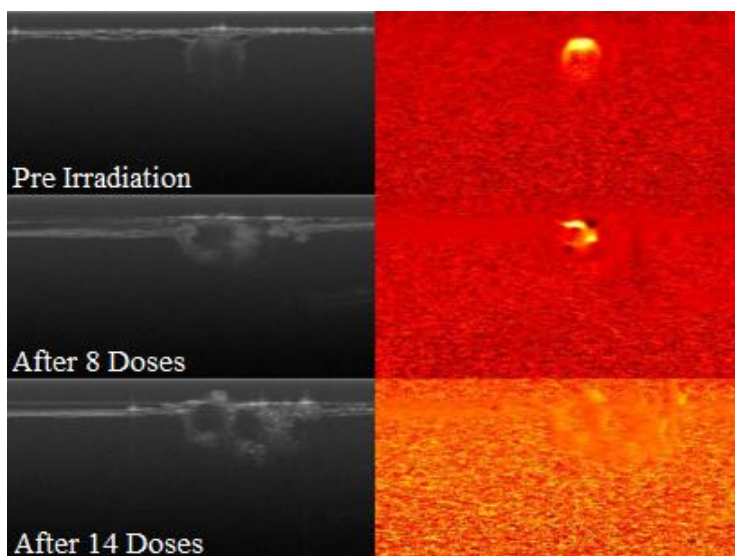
Doppler imaging as part of DS-Eval reveals residual flow despite the vessel being significantly denatured. To the naked eye this vessel appeared to have sealed after 8 doses. Top most images are pre-irradiation, middle after 8 doses, and bottom after 14 doses.
